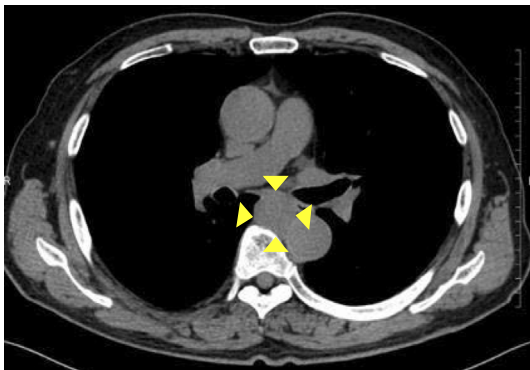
Computed tomography showed wall thickening of the esophagus (arrowheads).
